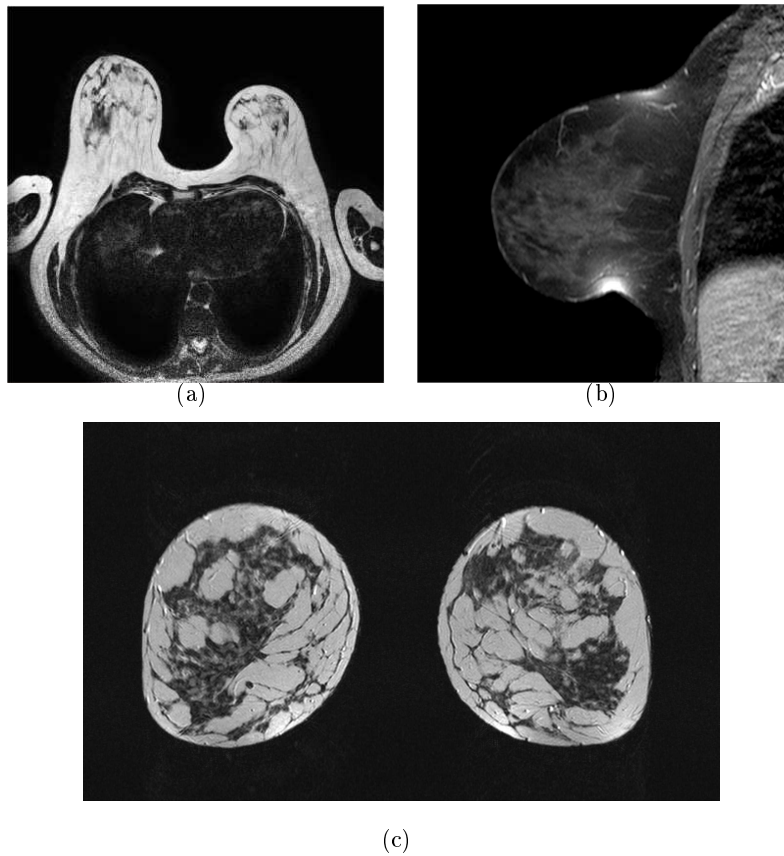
MRI viewpoints of the same patient: (a) shows axial view, (b) sagittal view, and, (c) coronal view.
